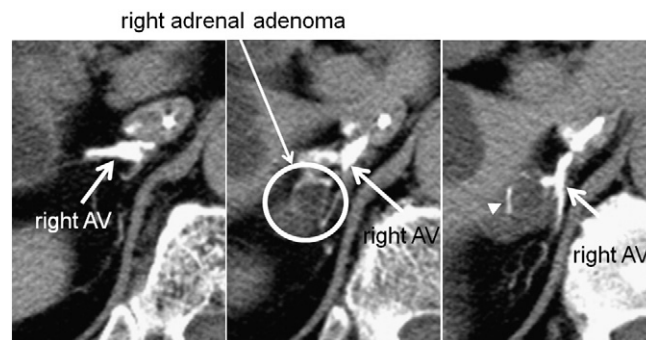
Typical images of selective retrograde computed tomographic adrenal venography (SRCTAV) acquired from a subject with right adrenal adenoma. Using SRCTAV, the right adrenal vein (AV) (arrows) can be clearly identified and anatomical information can also be acquired. Also the vein in the adrenal gland could be visualized (arrowhead).
